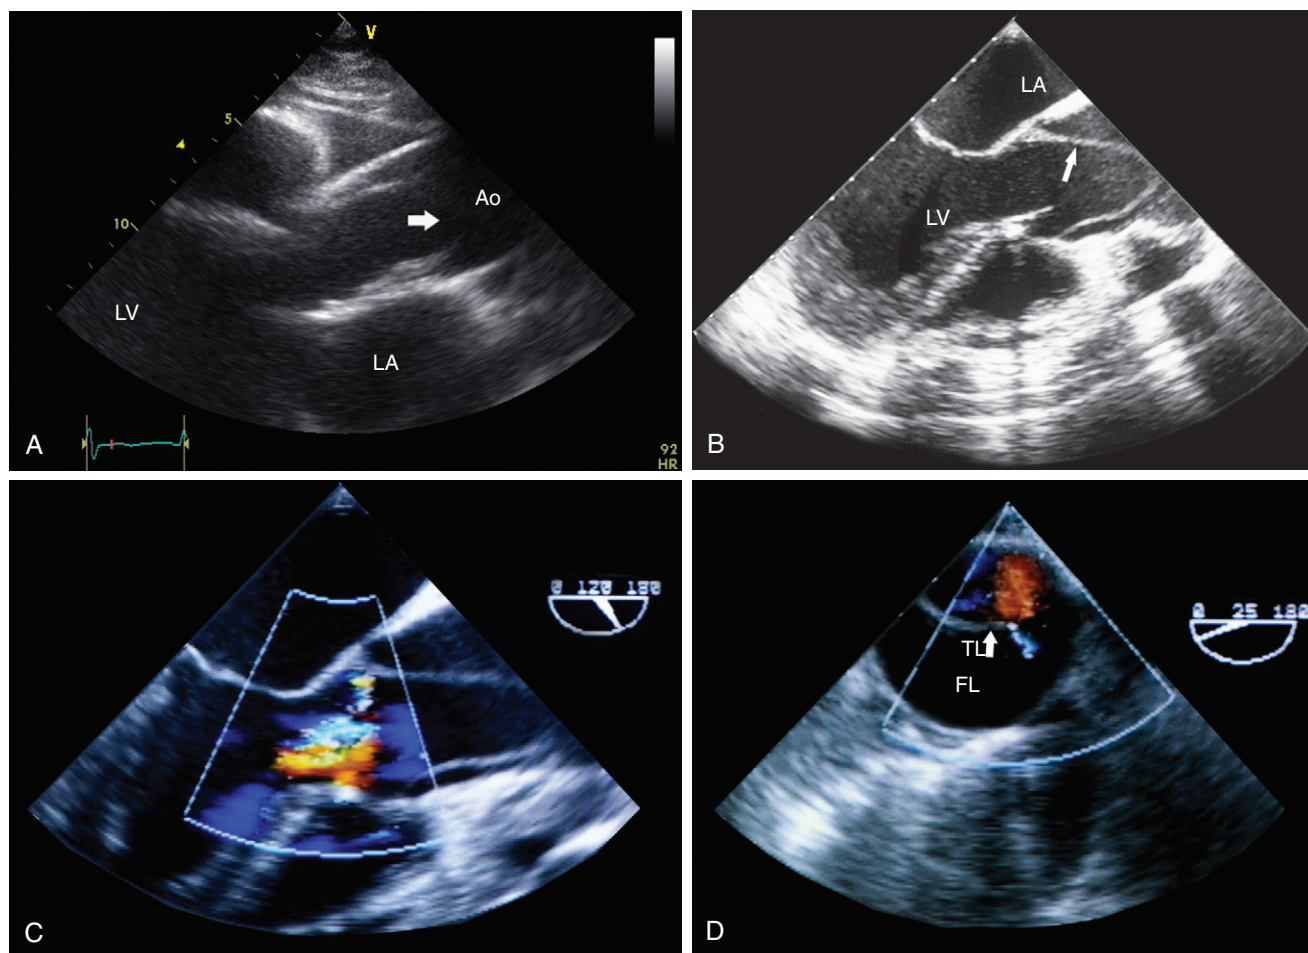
A, Transthoracic echocardiography shows a typical dissection of the ascending aorta, observed in the parasternal long-axis view, with the intimal flap (arrow) identified. B, Transesophageal echocardiography at the midesophageal level in the long-axis view (120 degrees) depicting the aortic dissection. C, Color flow Doppler revealed the associated aortic regurgitation. D, Short-axis view of the descending thoracic aorta shows communication between the true lumen (TL) and false lumen (FL), which are separated by the intimal flap (arrow). LA, left atrium; LV, left ventricle.
